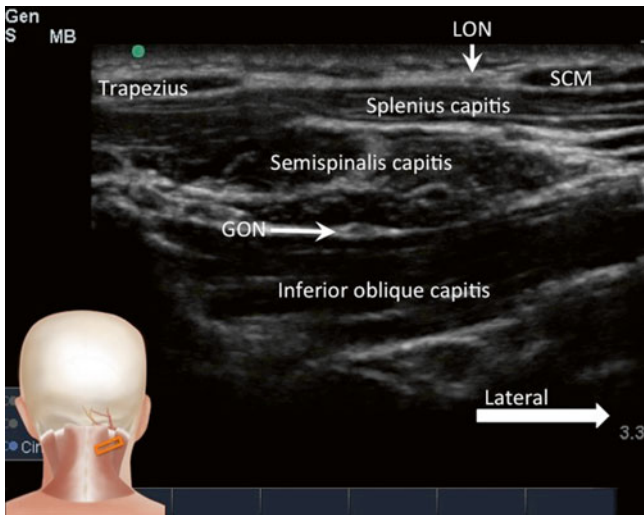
Sonogram at the same level as Fig. 12.6 but the probe is moved in the lateral direction with the lateral end of the probe tilted toward C1 lateral mass. The *insert* shows the probe position. *GON* greater occipital nerve, *LON* lesser occipital nerve, *SCM* sternocleidomastoid muscle (Reproduced with permission from Philip Peng Educational Series)
